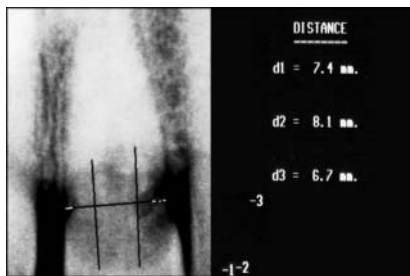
Digital radiography (Sens-a-Ray) allows distance measuring and can be used to provide views from different angles with a reduced dose of radiation.
